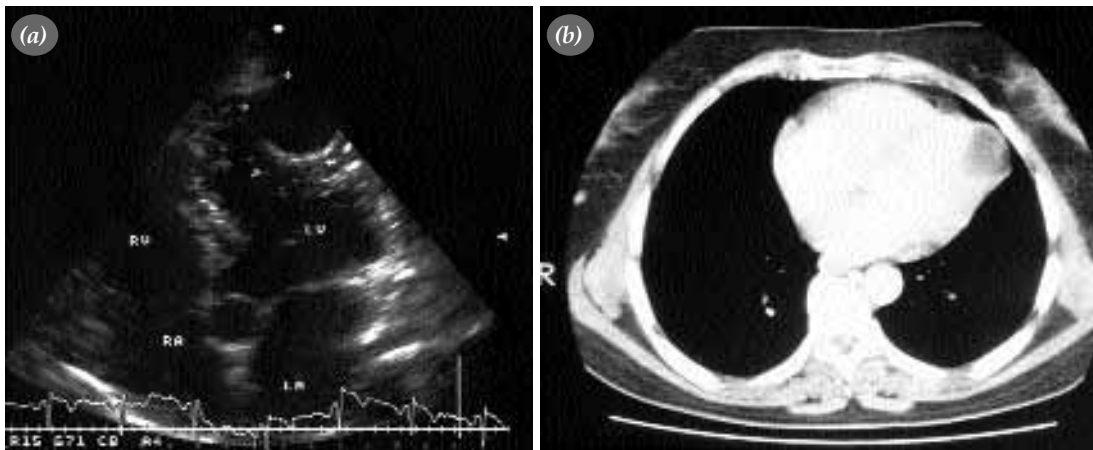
(a) Echocardiography revealed a cystic formation of 4.0 cm by 3.5 cm in diameter located on the lateral left ventricular wall (LA: Left atrium; LV: Left ventricle; RA: Right atrium; RV: Right ventricle). (b) Computed tomographic scan demonstrated a well-defined cystic lesion with regular borders on the lateral left ventricular wall.
